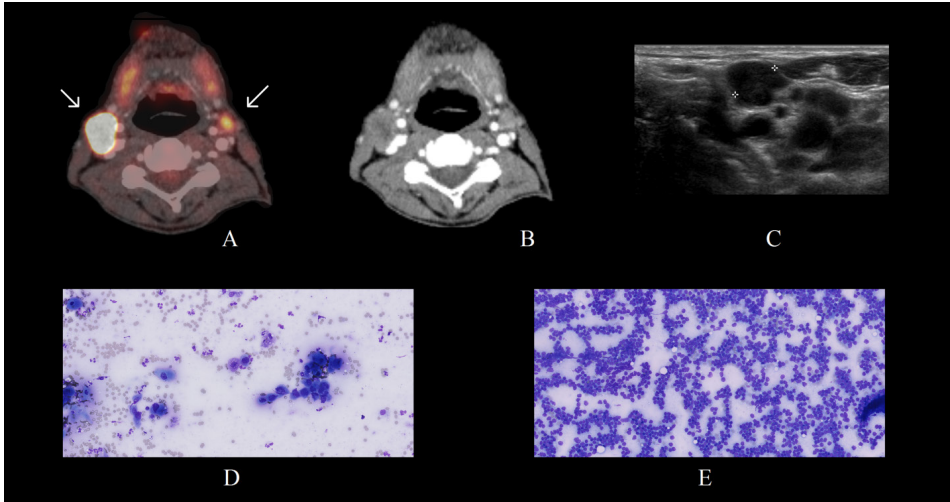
Examples of imaging and cytology: A. FDG PET-CT image, the white arrows point to lymph nodes. The large lymph node on the right side of the patient (left on the image) had a SUVmax of 12.13, the smaller node on the left had a SUVmax of 3.25. B. The corresponding CT image. C. The ultrasound image of the smaller node in the left neck, the distance between both crosses on the image is 0.8cm. D. Aspiration cytology of the right lymph node showing metastases (40x magnification). E. Aspiration cytology of the left lymph node without metastases (40x magnification).
